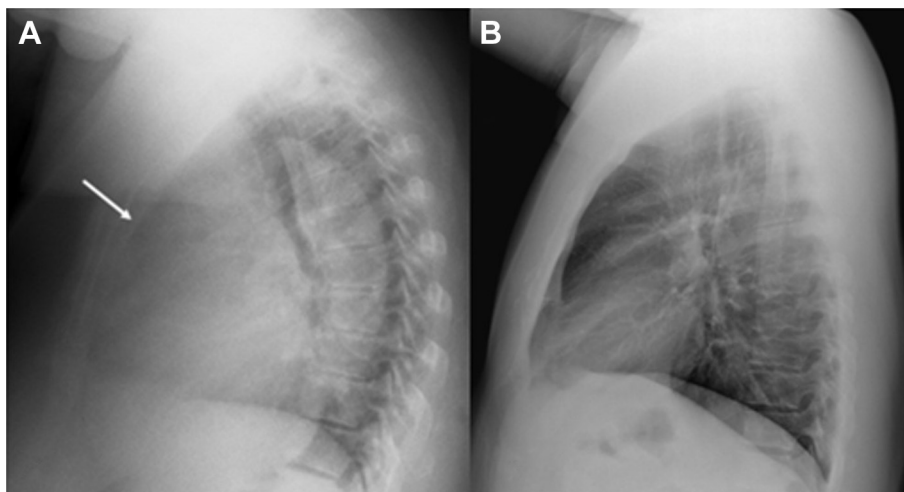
A, Lateral chest radiograph demonstrating fullness of the retrosternal space (arrow) commonly seen in right ventricular enlargement on the left. B, Normal lateral chest radiograph provided on the right for comparison.
